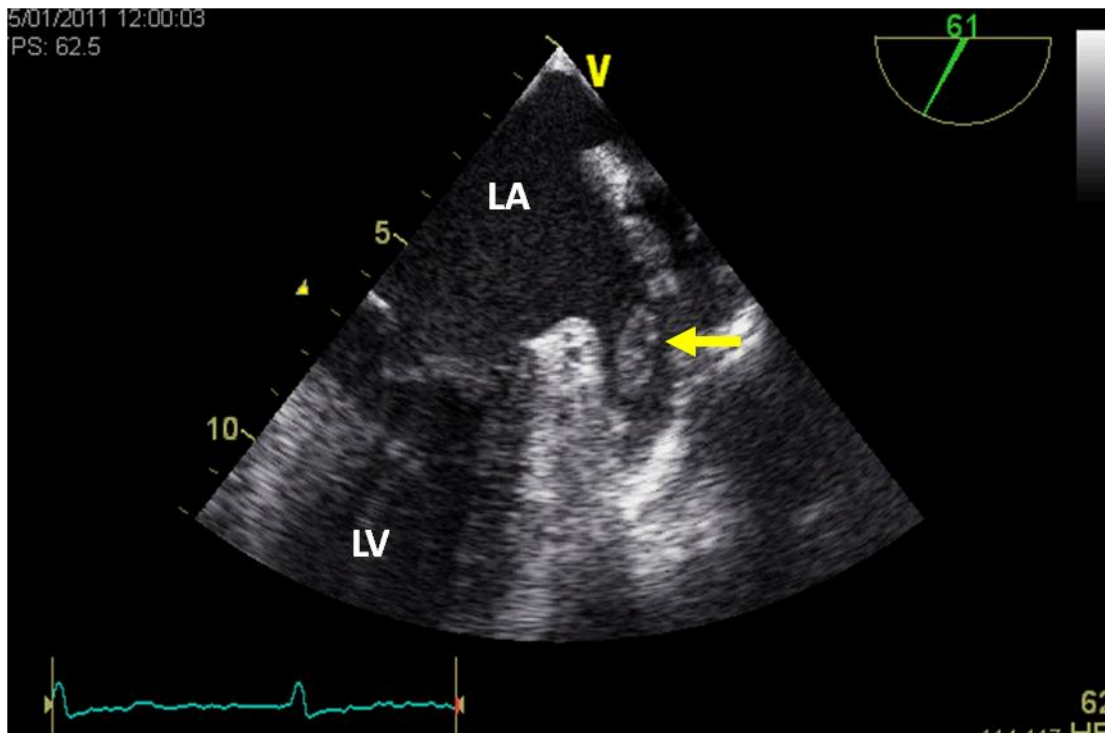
Two-dimensional transesophageal echocardiogram, midesophageal view, allowing the identification of an left atrial appendage thrombus (yellow arrow). LA, Left atrium; LV, left ventricle.
